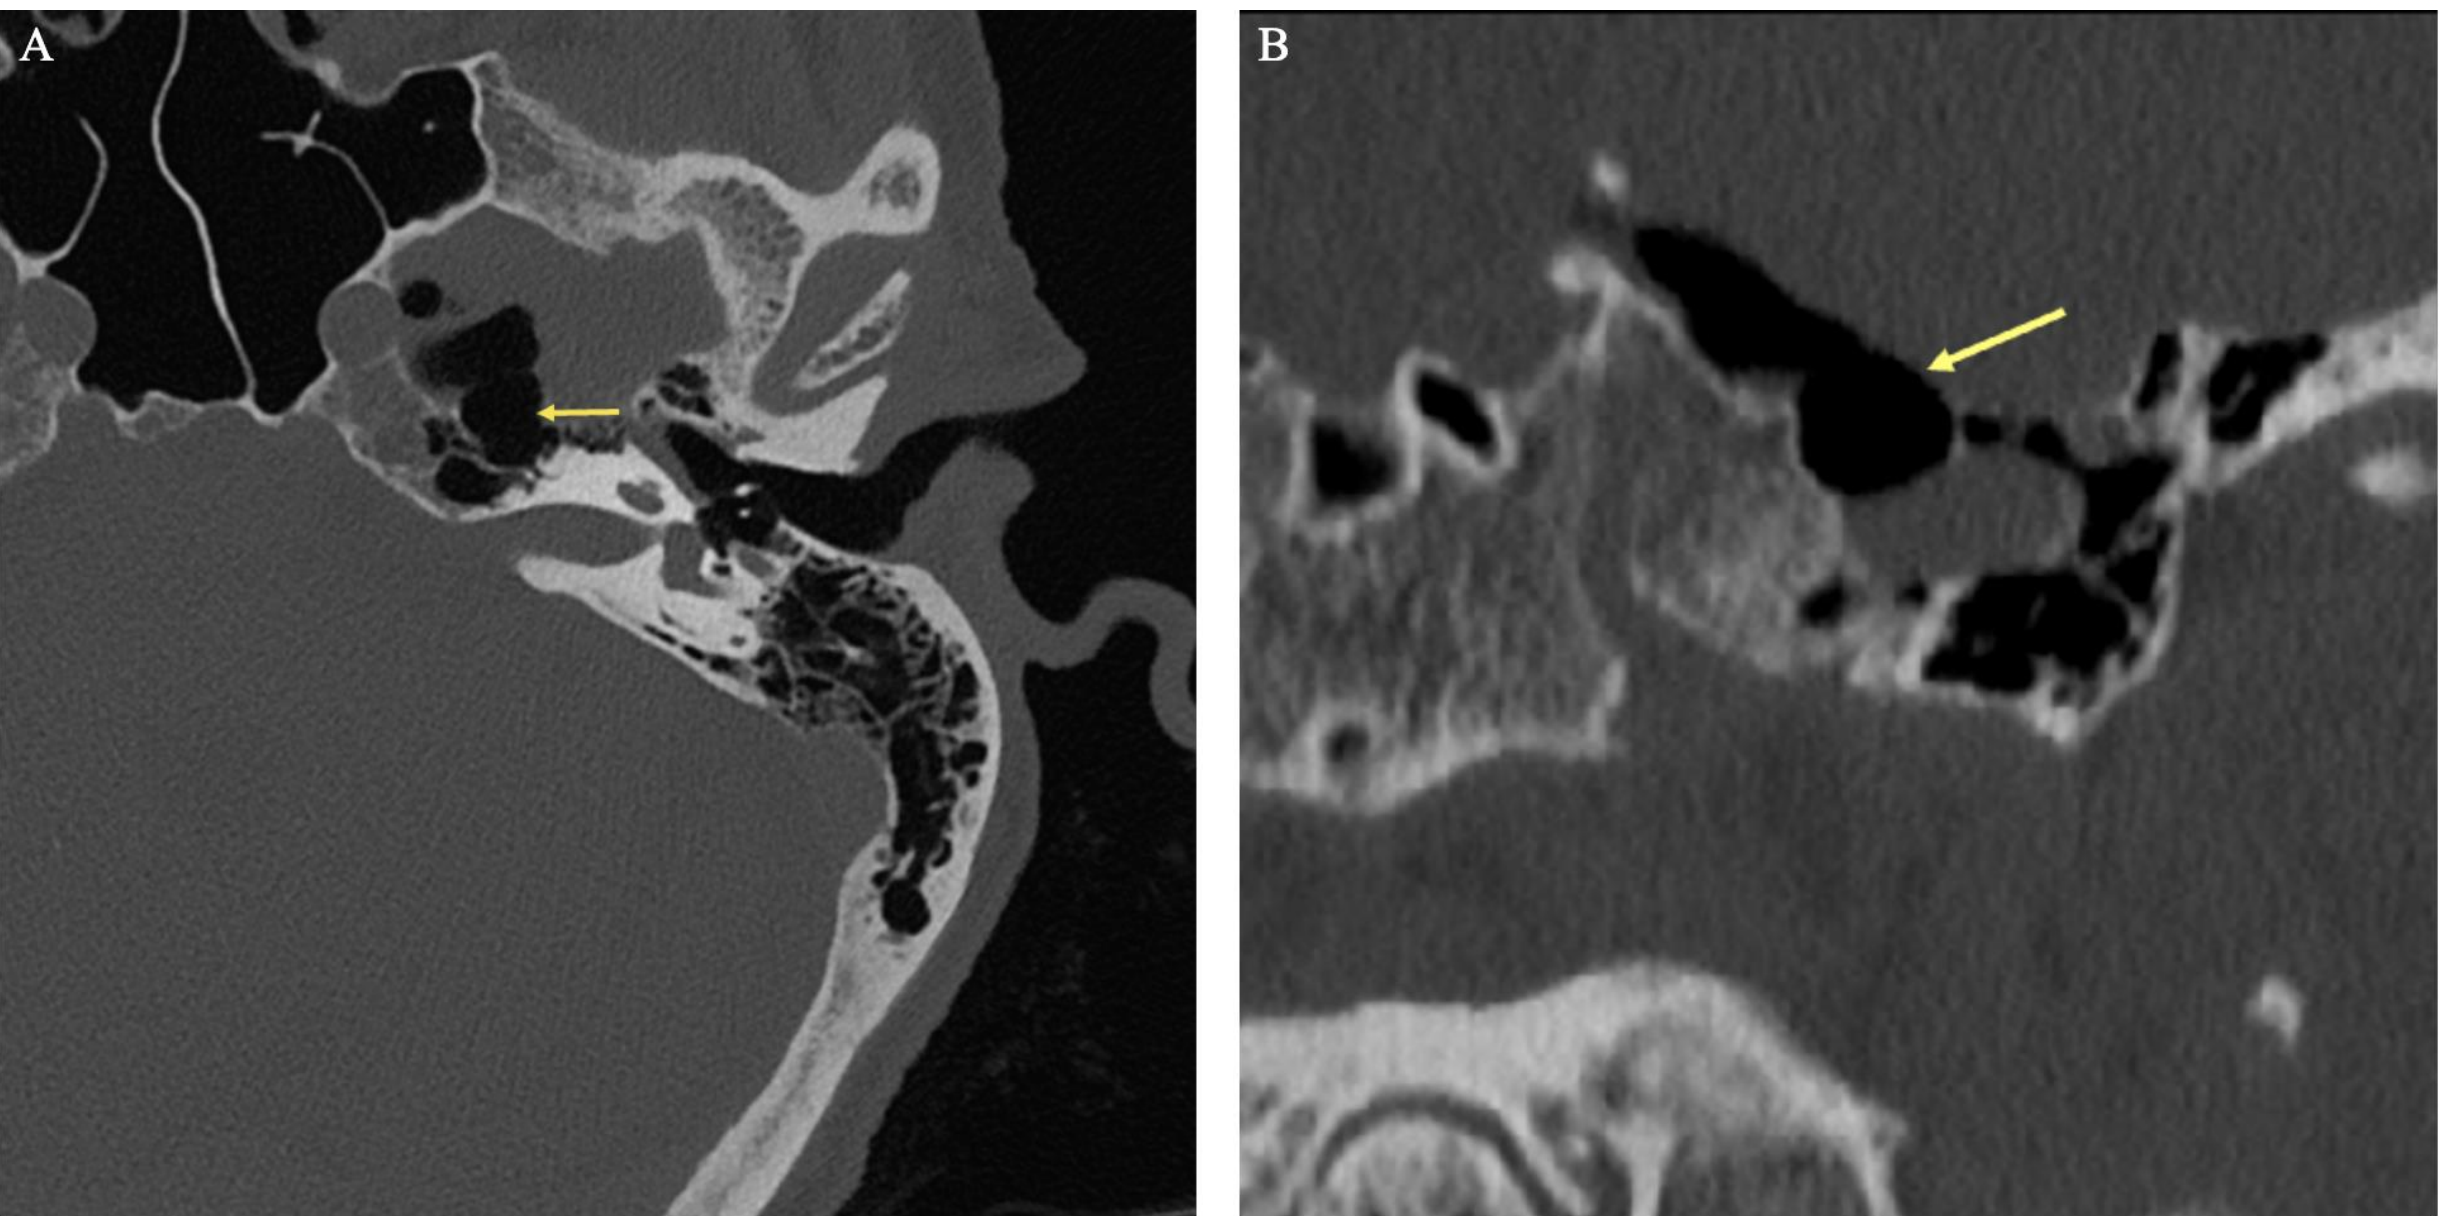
CT imaging of the temporal bone 1 week pre-operation. The yellow arrow on the coronal view (A) and axial views (B) depicts the skull base defect.
